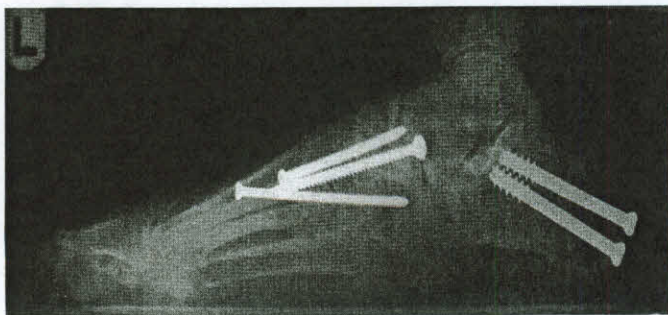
Postoperative lateral radiographic view of a patient's left foot in weight bearing.
